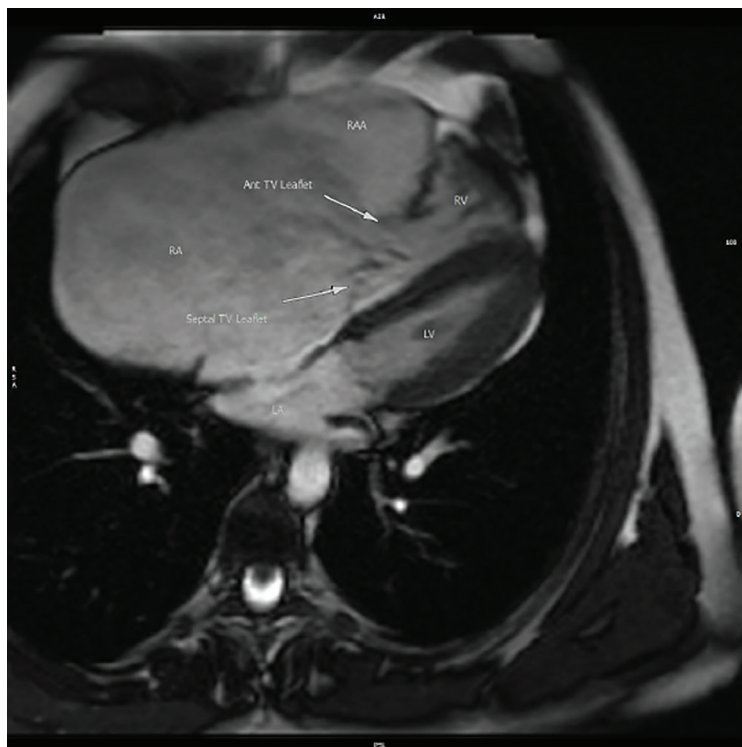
Magnetic Resonance Imaging of the Severely Dilated Right Atrium in the Four-Chamber View
